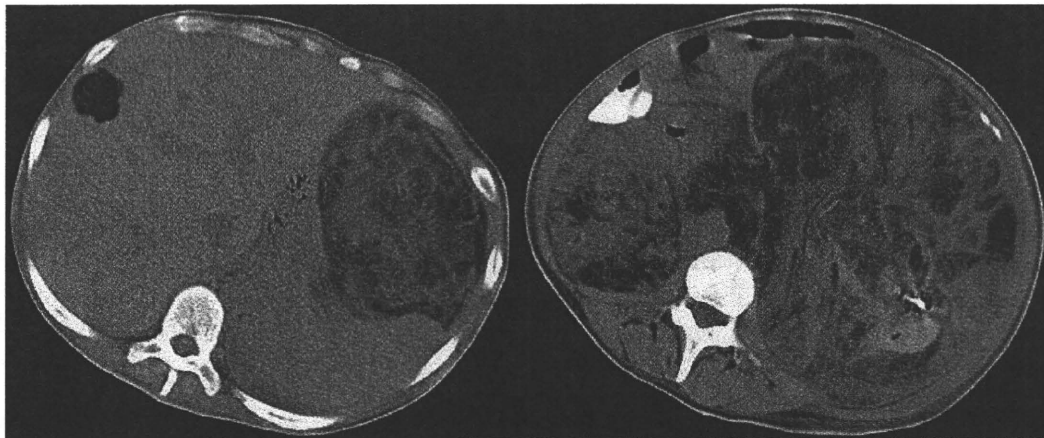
Giant bilateral renal angiomyolipomas in abdominal computed tomography (Case 7). Giant bilateral renal angiomyolipomas are shown in abdominal computed tomography. A hepatic angiomyolipoma is also shown. The patient experienced abdominal distention which was a symptom related to renal angiomyolipomas at the time of diagnosis.
